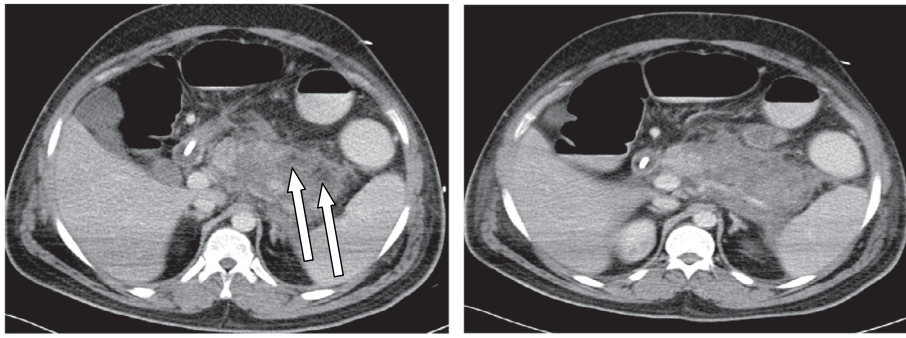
(A and B) CT scan with IV contrast shows severe diffuse pancreatic swelling with heterogeneous patchy enhancement and multiple non enhancing necrotic foci (arrows).
